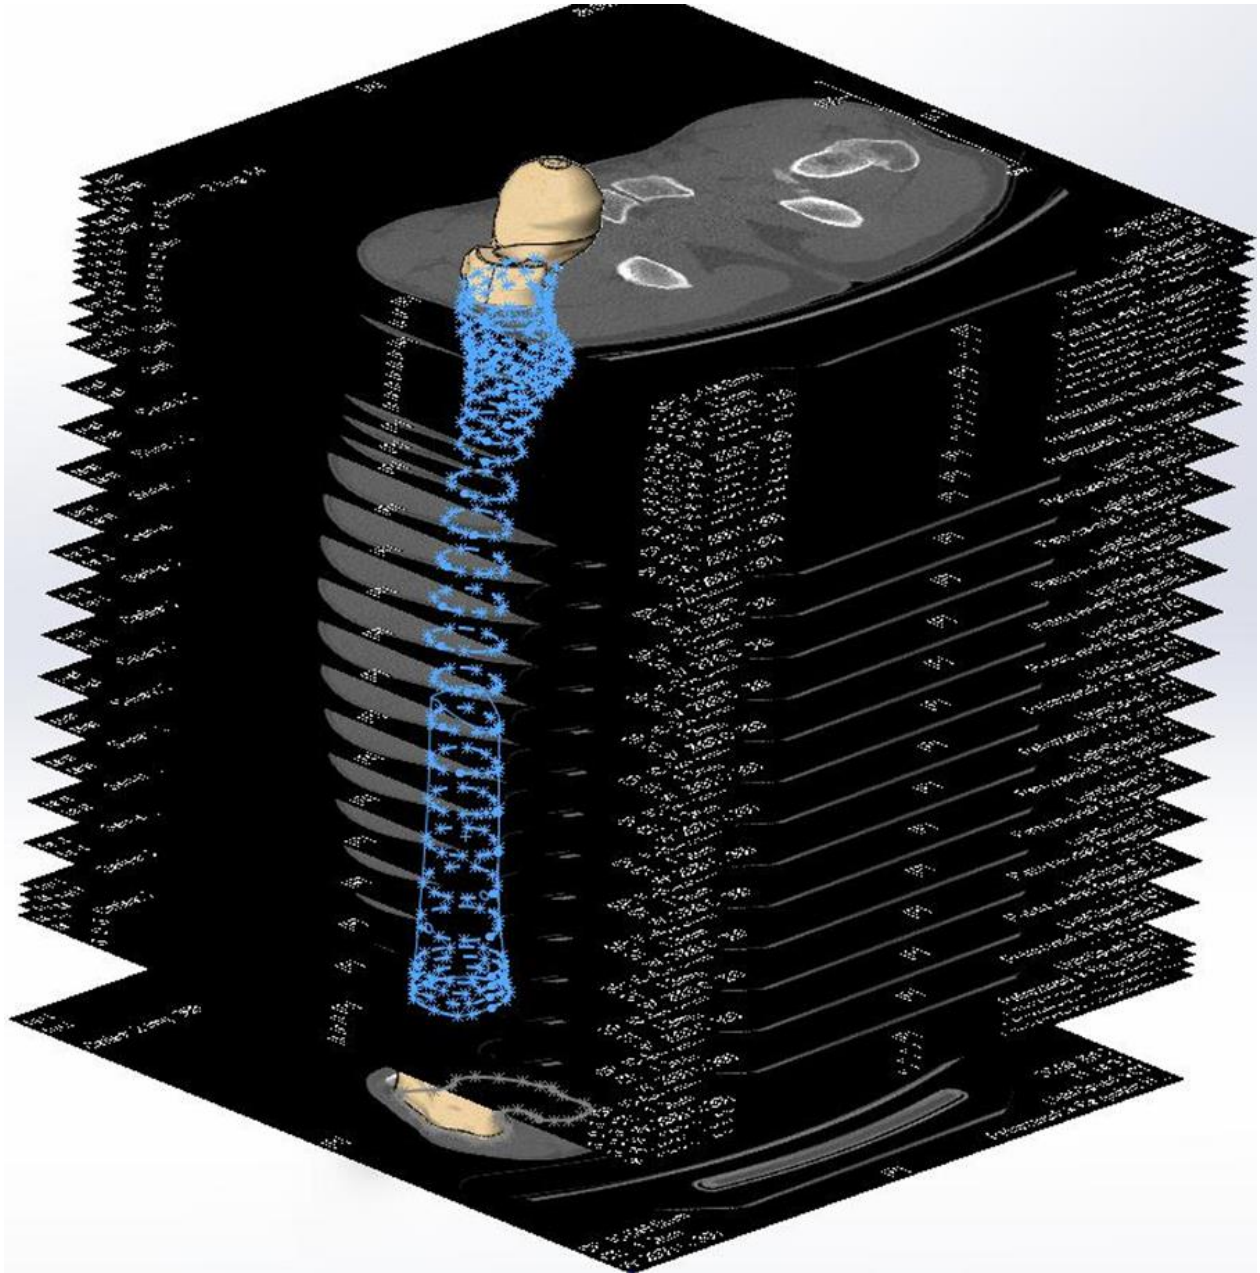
CT images and 3D model of human femur bone
